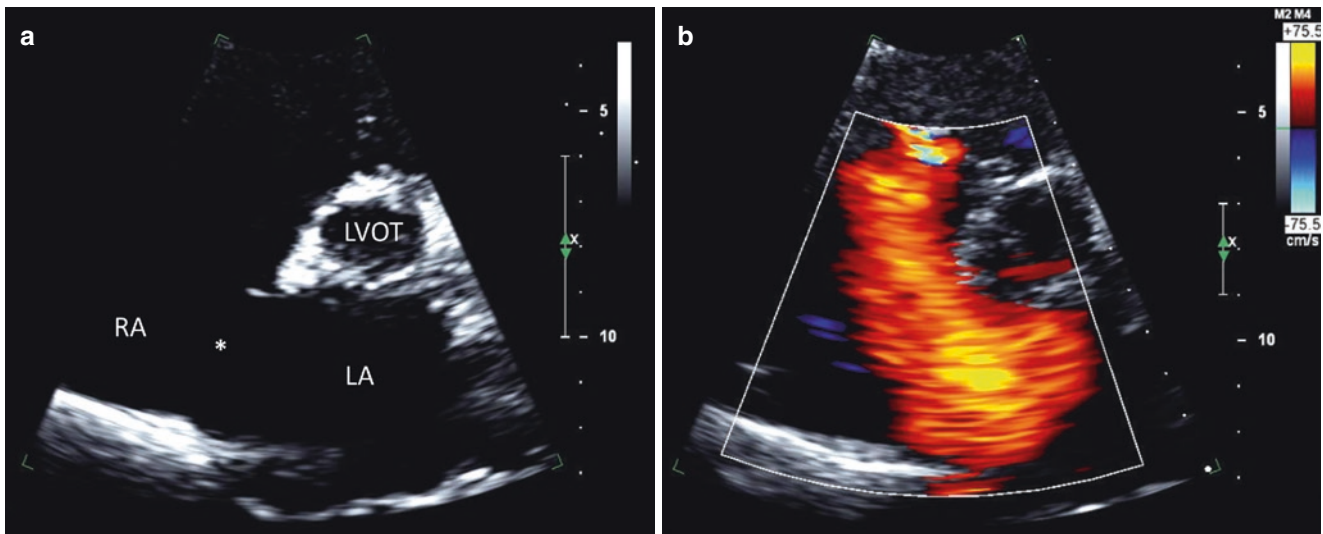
Secundum atrial septal defect. (a) Parasternal short-axis view showing a large secundum atrial septal defect (asterisk). (b) Color-flow Doppler shows a large left-to-right shunt across the atrial
